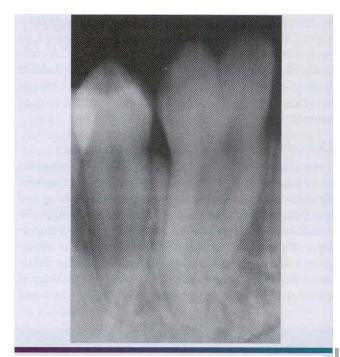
• Fusion. Radiograph of the same patient depicted in Figure 2-57. Note the bifid crown overlying the single root canal; the contralateral radiograph revealed a similar pattern.
